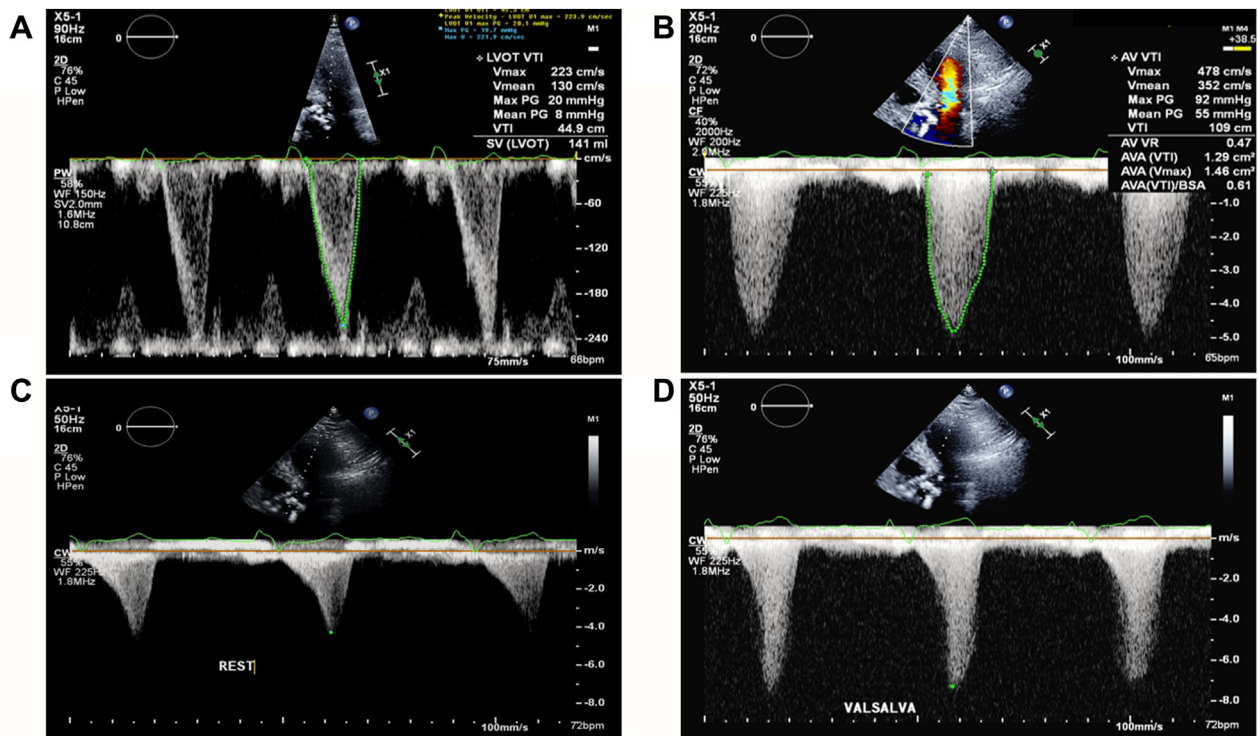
Case 2: Two-dimensional TTE, apical five-chamber view, pulsed-wave Doppler (A) and CWD (B-D) spectral displays, demonstrates a Doppler profile that peaks in late systole (A); 2.2 m/s, a fixed, severe AS Doppler profile that peaks in midsystole (B); 4.8 m/s, a late-peaking, functional Doppler profile at rest (C); 4.3 m/s, and a late-peaking dynamic LVOT obstruction Doppler profile during the Valsalva maneuver (D); 7.3 m/s).
